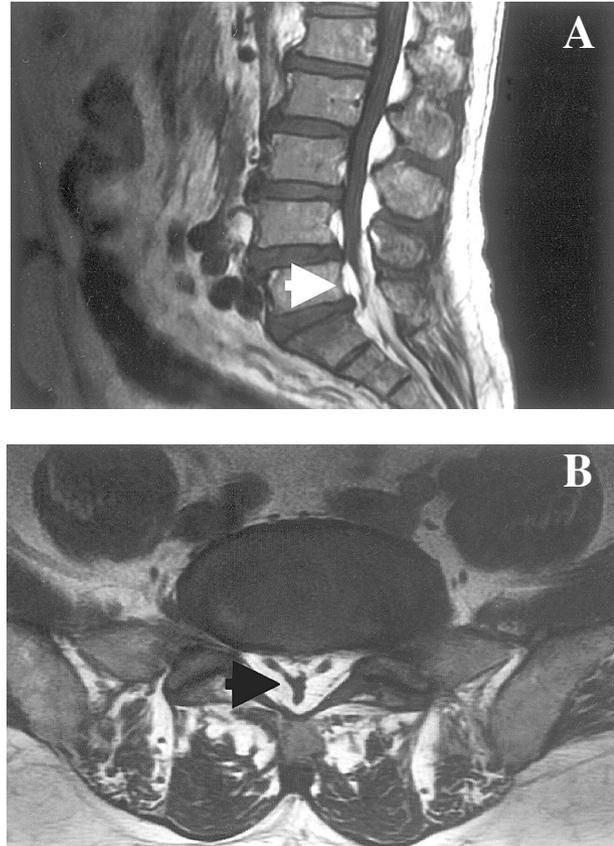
T1-weighted MRI at lumbar-sacral level (Case 1) showed high intensity adipose tissue compression of the spinal nerve roots, lying at anterior aspect of thecal sac. (A) The T1-weighted sagittal image revealed the hypertrophy of adipose tissue deposition at the anterior aspect of spinal canal extending from L3 to S1 level (white arrow). L3-4, L4-5 bulging intervertebral disc was also demonstrated. (B) The T1-weighted axial image revealed the typical "Y" or "Stellate" configuration of the thecal sac (black arrow).
